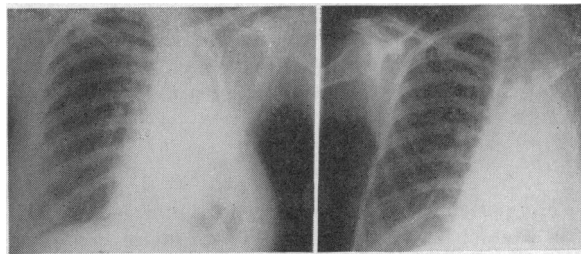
Roentgenograms shortly before (*left*) and after (*right*) pneumonectomy, showing an almost identical appearance.
